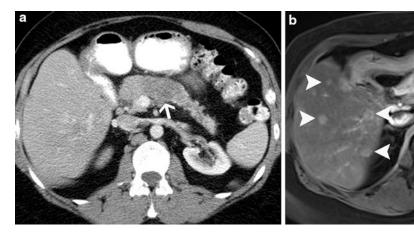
Pancreatic neuroendocrine tumor. Axial enhanced CT (a) shows hypodense mass (*arrow*) in the body of the pancreas proven to be a neuroendocrine tumor. Axial, fat-suppressed, enhanced MRI (b) at the same level
